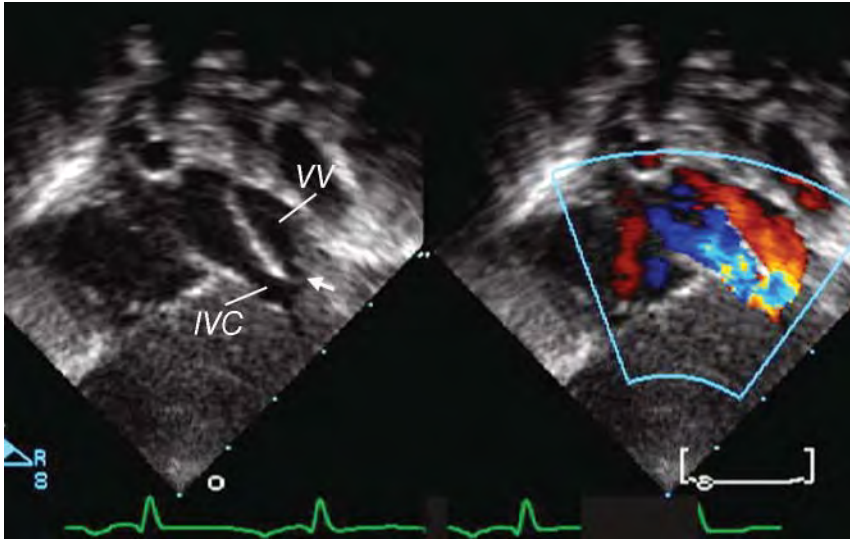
Infradiaphragmatic TAPVC. The subxiphoid short axis echocardiogram view in this patient with infradiaphragmatic TAPVC with two-dimensional and color Doppler flow mapping shows the vertical vein (VV) descending just below the level of the diaphragm, and then coursing anteriorly to drain directly into the inferior vena cava (IVC). Note the narrowing of the venous connection to the IVC (arrow), with color Doppler flow acceleration at the connection to the IVC.
